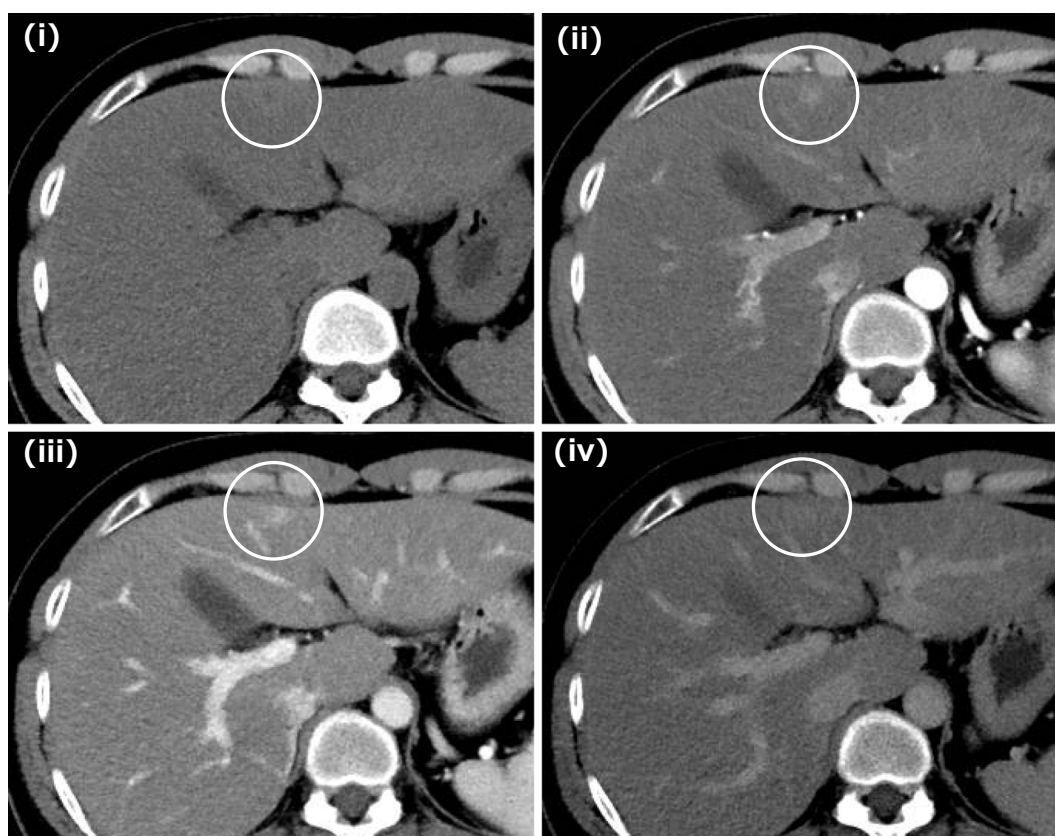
Plain CT showed unclear boundary, low-density area in S4 (i). Dynamic CT showed hyper-enhancement in the arterial phase (ii), hyper-enhancement in the portal phase (iii), and iso-enhancement in the delayed phase (iv).
